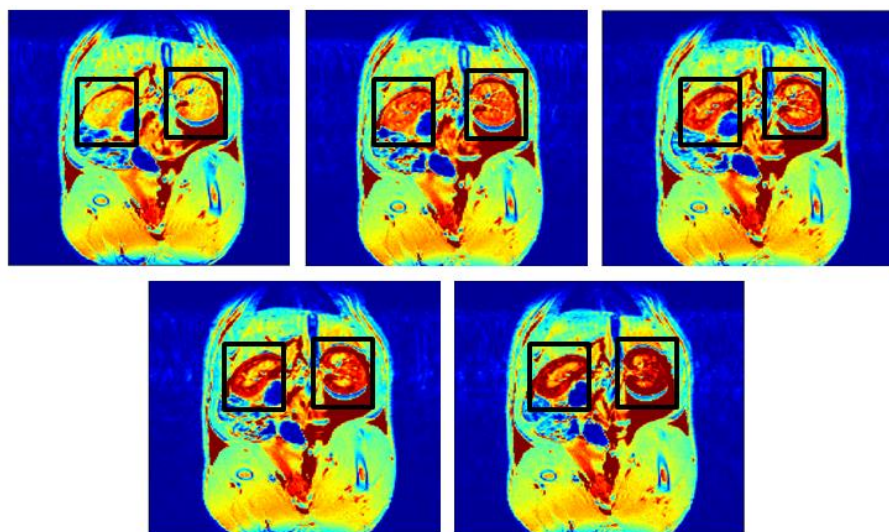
Change in MRI signal intensity over the first 45 minutes post-injection of 1.1 ( $\text{Mn}^{\text{II}}\text{-N}_5$ ). The baseline scan was collected at  $t = 10$  mins.
